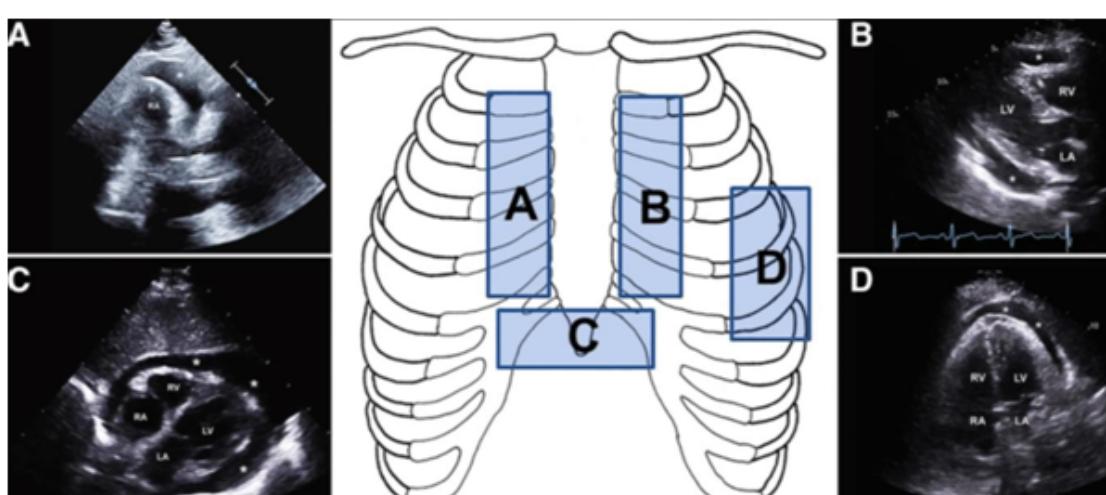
Sites for echocardiographic-guided pericardiocentesis. A. Right parasternal B. Left parasternal C. Subxiphoid D. Apical.
